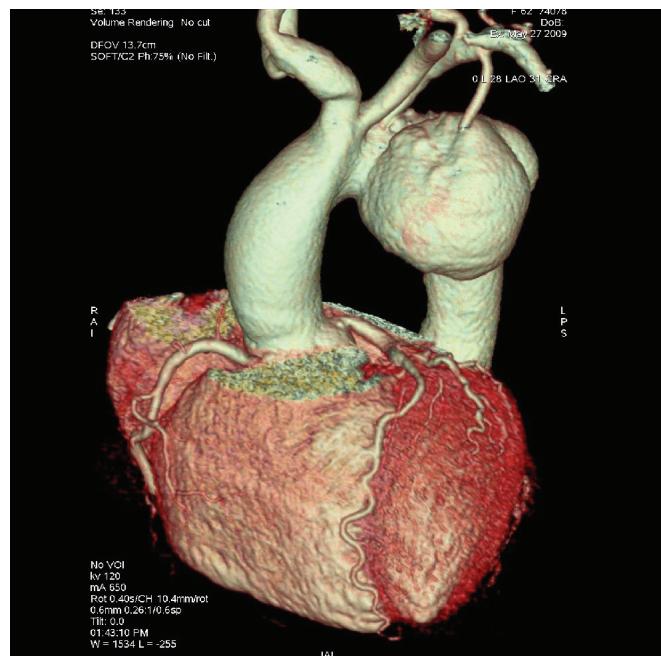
Computed tomography scan of the chest. The volume-rendered reconstruction shows a large saccular aneurysm arising from the arch of the aorta along its inferolateral wall at the level of the origin of the left subclavian artery.
